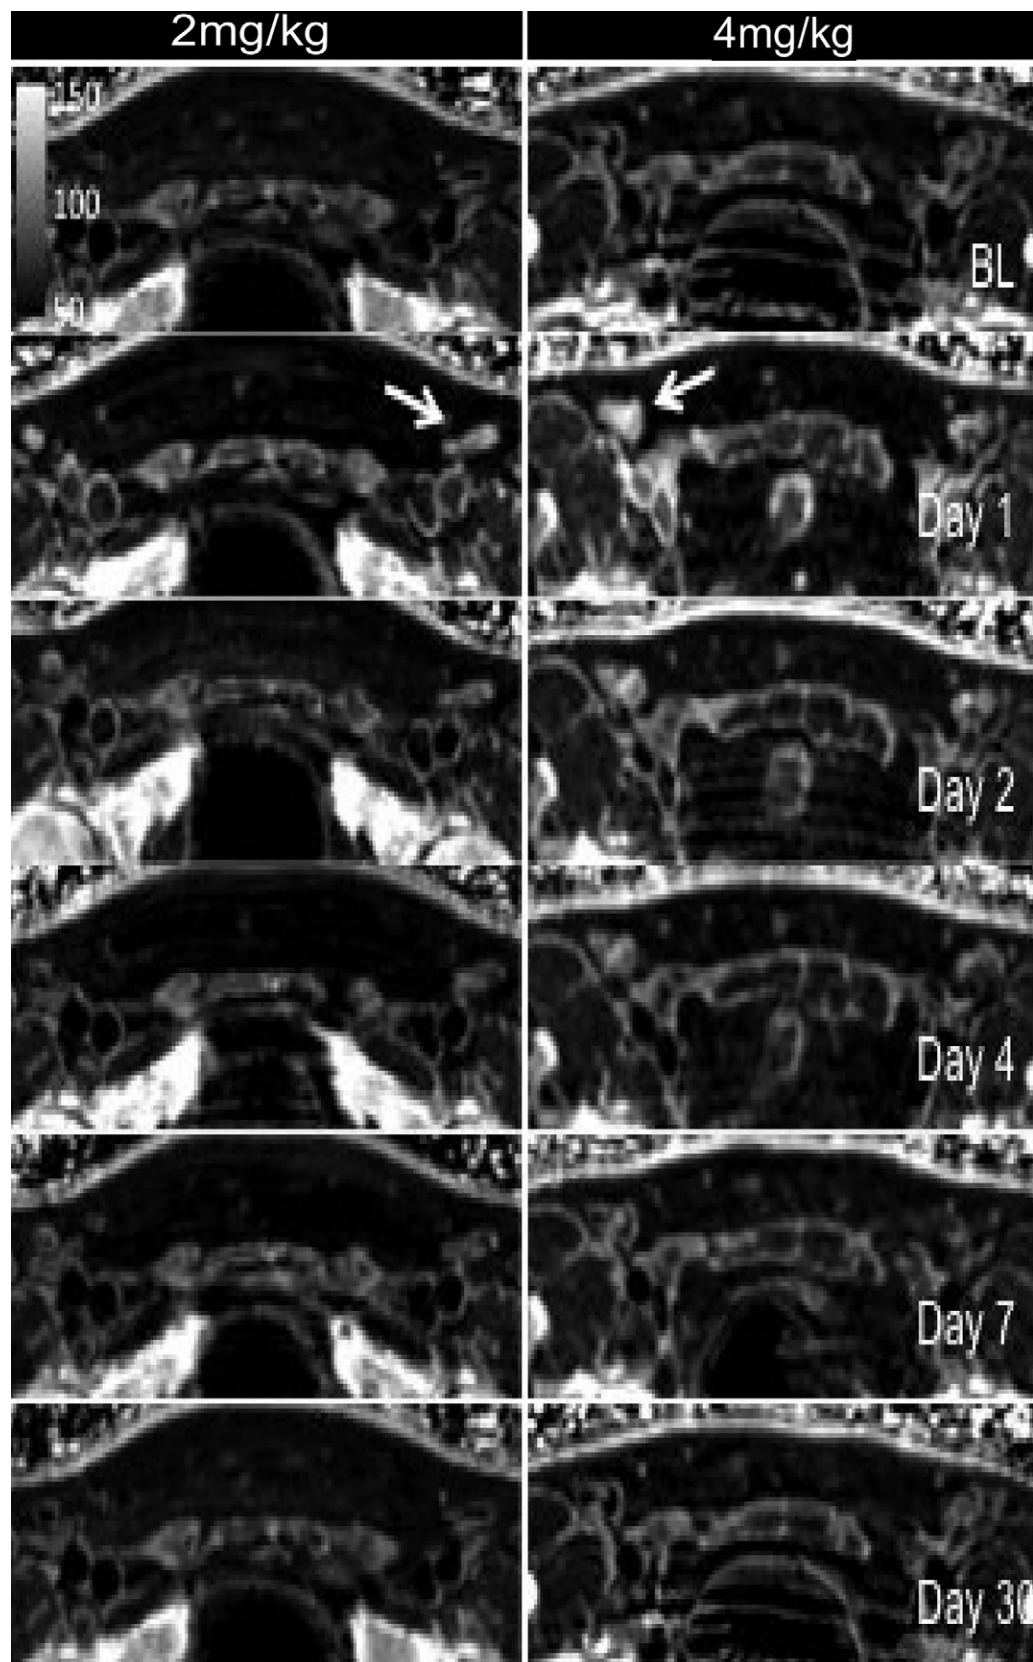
R2* maps of the pelvis in a volunteer who received 2 mg/kg ferumoxytol (FE) (left) and a volunteer who received 4 mg/kg FE (right) show the biodistribution and clearance of FE in inguinal lymph nodes (arrows) at 1.5-T MRI at baseline (BL) and across visits (days 1, 2, 4, 7, and 30). Window level was set to 220 sec⁻¹, and window width was set to 440 sec⁻¹ for all images.
